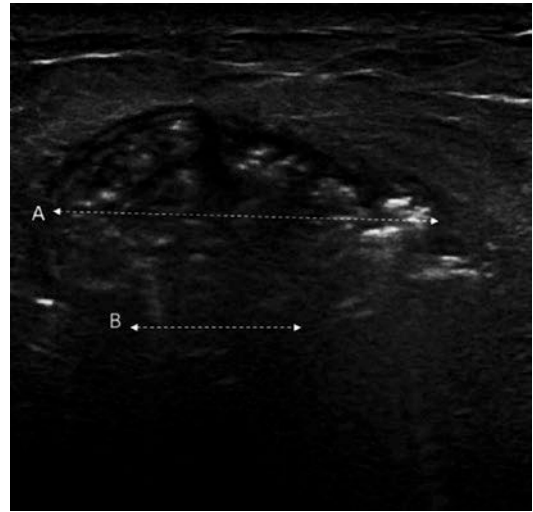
Incisional hernia. Ultrasonography shows bowel loops (A: caliper) through a defect (B: caliper) of the abdominal wall
